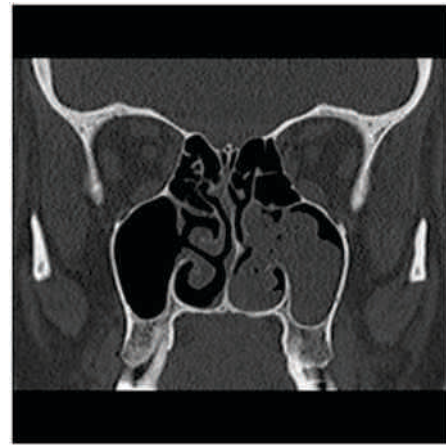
CT Scan Coronal Section Left Side Polyp.
